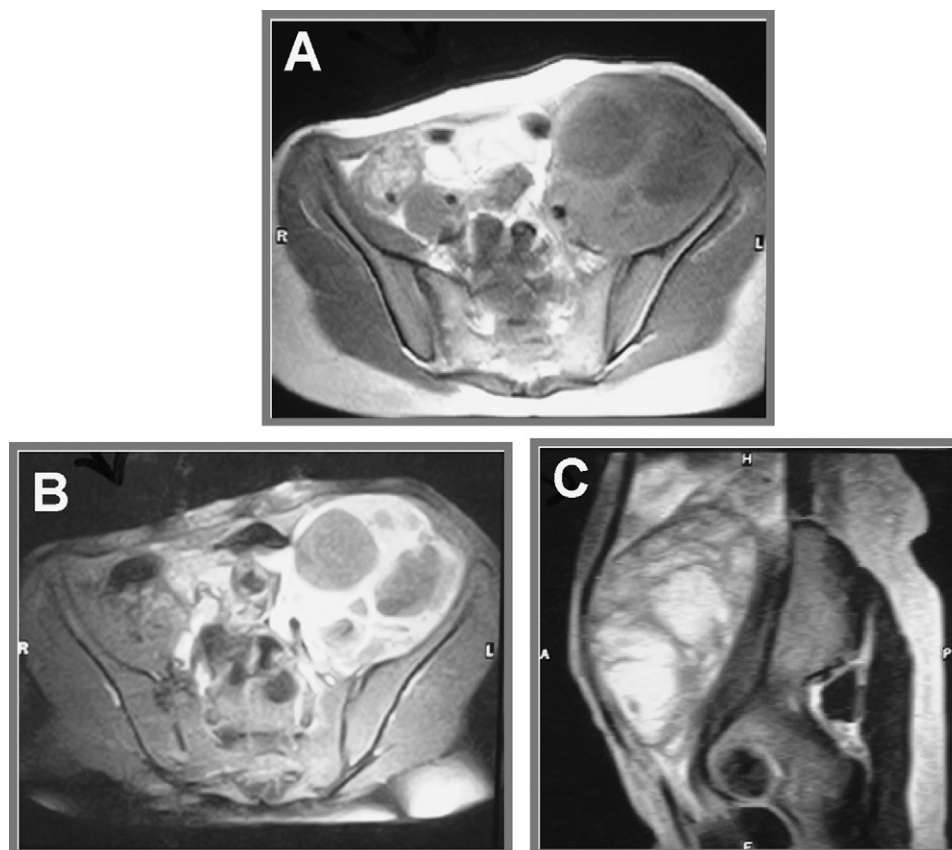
(A) Pre-contrast and (B) post-contrast axial T1-weighted and (C) sagittal T2-weighted MRI examinations.
